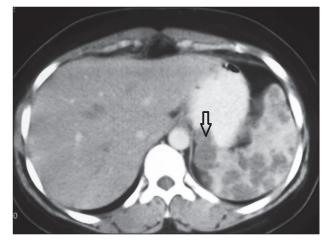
Computed tomography: Multiple nonenhancing hypodense lesions in the liver and spleen
